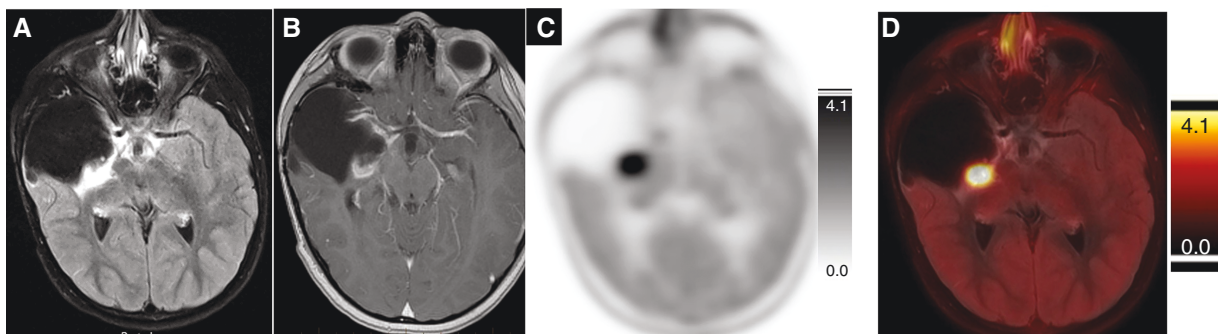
Fibrillary astrocytoma, previously resected. (A) Axial FLAIR image through the temporal lobe demonstrated an area of nodularity, suspicious for recurrence, at the posteromedial aspect of the large cystic resection cavity from prior resection of a large fibrillary astrocytoma, some component of which demonstrated minimal enhancement on post contrast T1 weighted image (B). The Attenuation corrected [¹¹C]-MET-PET image (C) demonstrated intense uptake of the tracer over the focal nodularity, as shown on the overlay image (D) with a TBR_{max} of 4.27.
